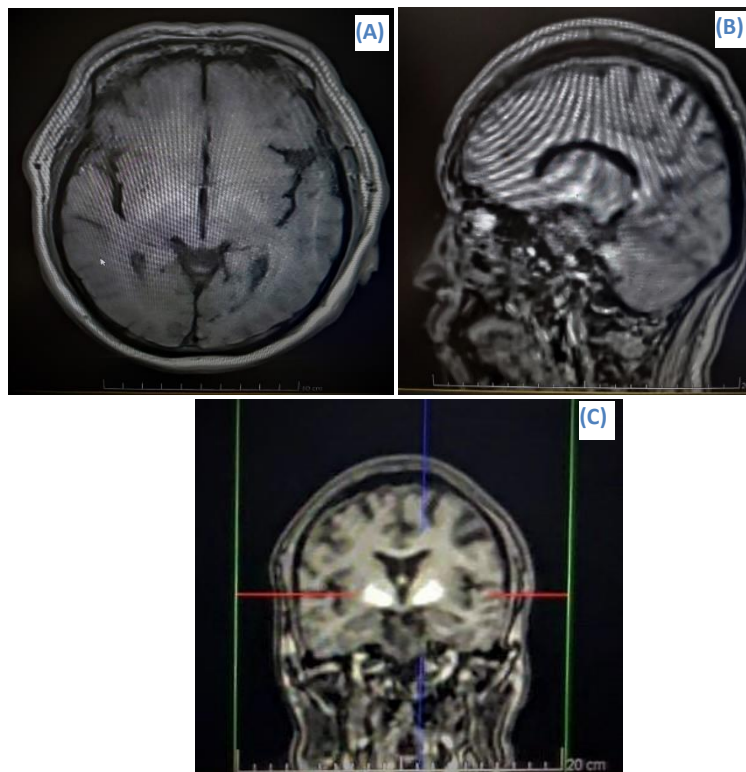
(A) This is the T1 (A) Axial Flair MRI Image of Patient Which Shows Symmetrically Increased Intensity Over The Mammillary Body Region In (B) Sagittal (C) Coronal.
